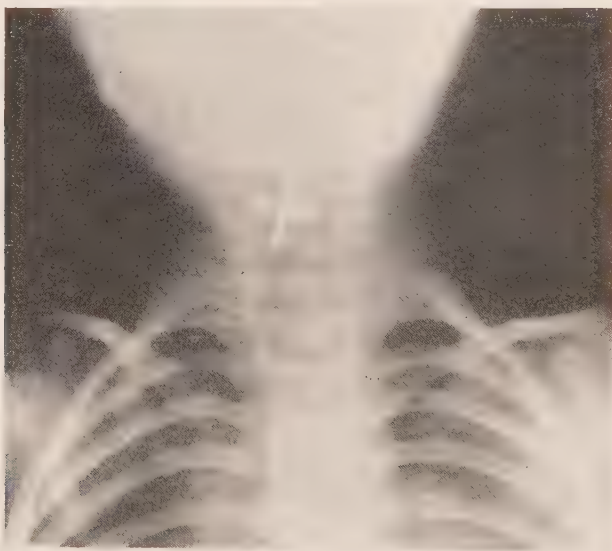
Roentgenogram showing a jack-stone in the upper end of esophagus. For three weeks the child had not been able to take solid food, although liquids were easily swallowed. (Roentgenogram by Dr. G. C. Bird.)
